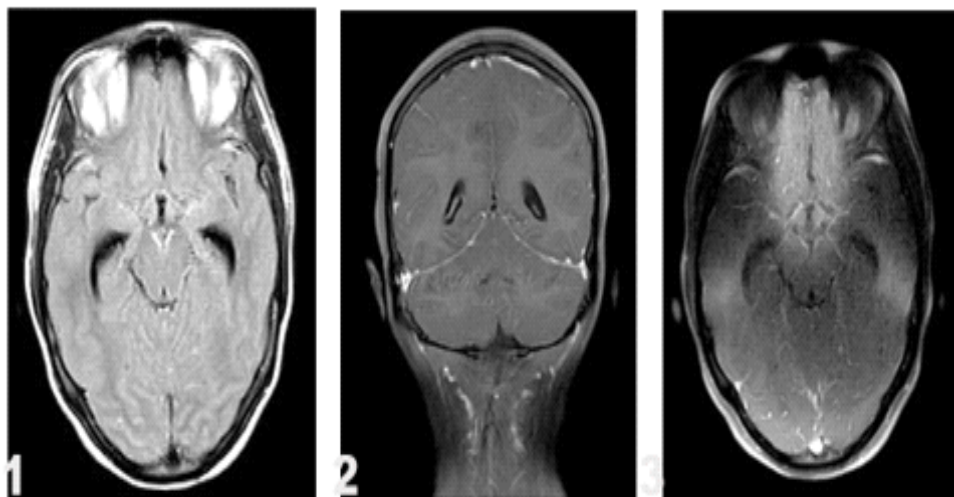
MRI brain showing mixed signal intensity and post-contrast enhancement in the interpeduncular cisterns and bilateral parietal sulci.
